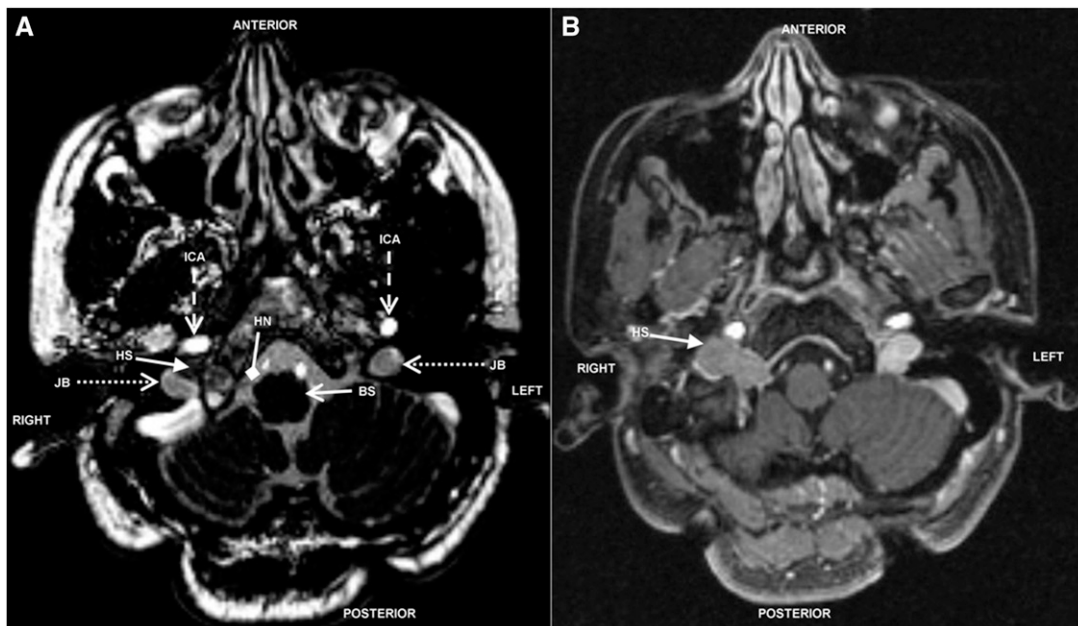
(A) T2-weighted axial magnetic resonance (MR) image of the patient showing the posterior fossa structures, with “open arrow” pointing at the brainstem (BS), and “diamond arrow” showing the hypoglossal nerve (HN) exiting the brainstem between the pyramid and the inferior olive, and exiting the skull base through the hypoglossal foramen. The “open arrows with dashed line” show the bilateral internal carotid arteries (ICA) in the petrous bone. The “open arrows on dotted line” show the bilateral jugular bulbs (JB). The “closed arrow” points at the hypoglossal schwannoma (HS) arising from the hypoglossal nerve (HN) and occupying the JF between the right ICA anteriorly and right JB posteriorly. It is at this location that the tumor is compressing upon the rootlets of the spinal accessory nerve (CNXI). (B) Contrast-enhanced T1-weighted axial MR image of the patient showing the HS depicted by the “closed arrow.”
